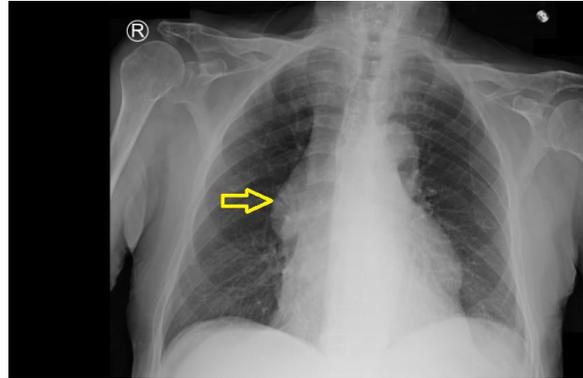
Postero-anterior chest X-ray showing widened mediastinum suggestive of anterior mediastinal mass (arrow).
